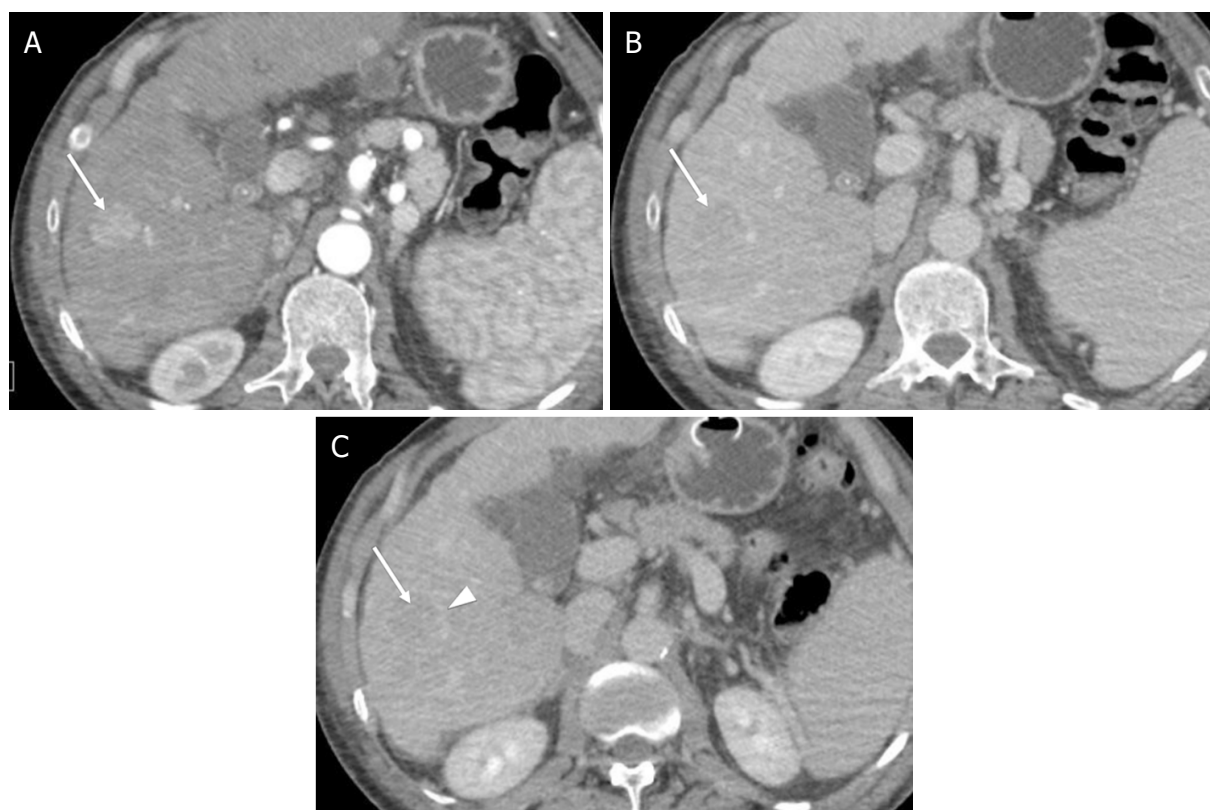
LR-5 (Definite hepatocellular carcinoma). Axial computed tomography in a 60-year-old man with hepatitis C cirrhosis. Arterial phase (A); portal venous phase (B); and delayed phases (C) demonstrate a 21-mm observation with nonrim arterial phase hyperenhancement [arrow (a)], nonperipheral washout appearance [arrow (B,C)], and enhancing capsule appearance [arrowhead (c)]
